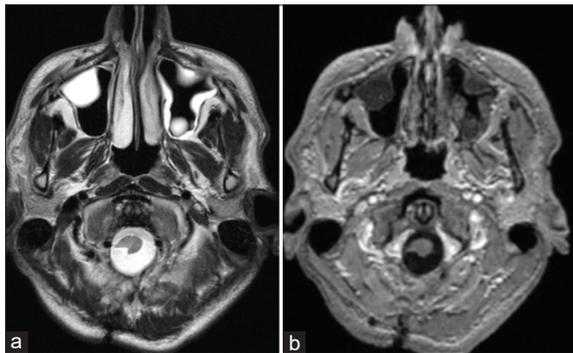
Postoperative MRI in 24 months. (a) T2-weighted image, axial plane. No sign of tumor. (b) Contrast enhancement axial T1. No contrast enhancement at the level of the spinal cord.
